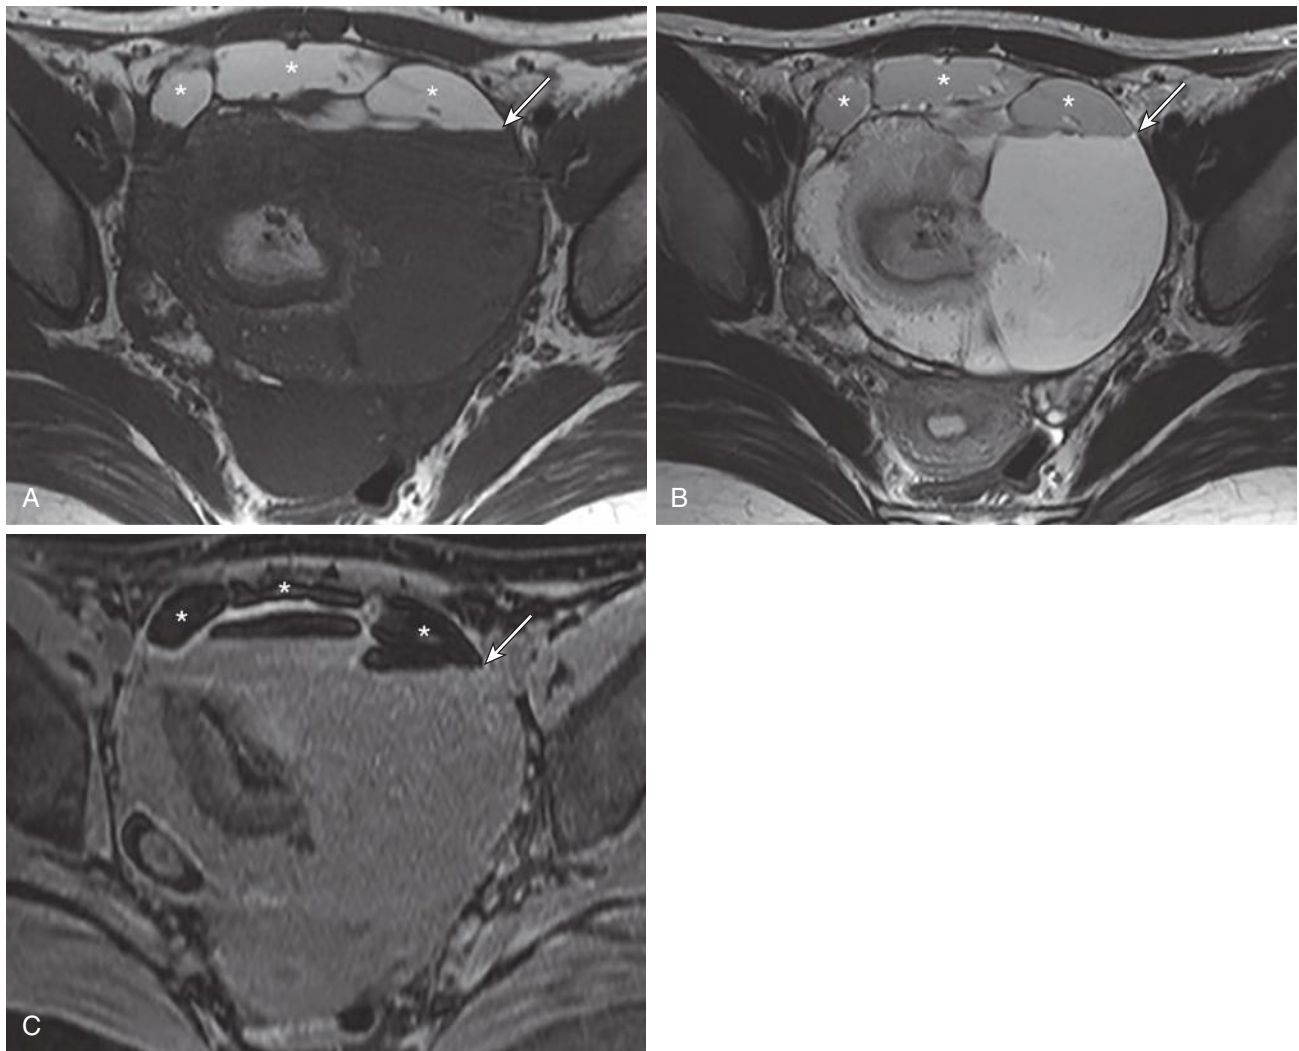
Benign mature cystic teratoma of the ovary. Axial T1-weighted (A), T2-weighted (B), and fat-saturated T1-weighted (C) images. Complex adnexal mass with fat-fluid level (arrows). Areas of increased signal intensity (asterisks) on T1-weighted (A) and T2-weighted (B) images and corresponding low signal intensity on fat-saturated T1-weighted image (C) are consistent with macroscopic fat, characteristic of a teratoma. (Courtesy of Lisa M. Ho, MD, Duke University, Durham, NC.)
